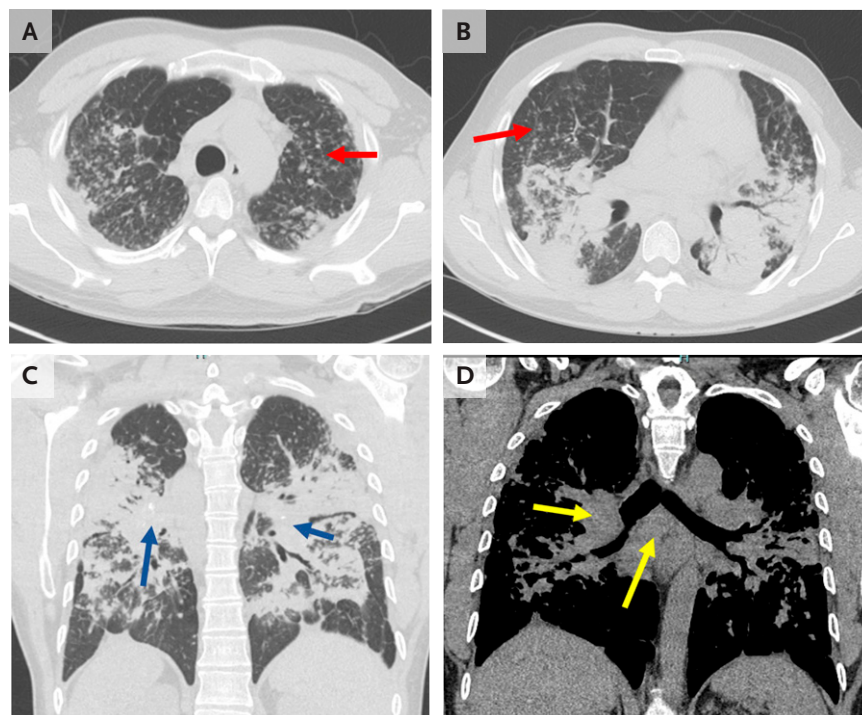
CT Imaging of the Chest without Intravenous Contrast.
